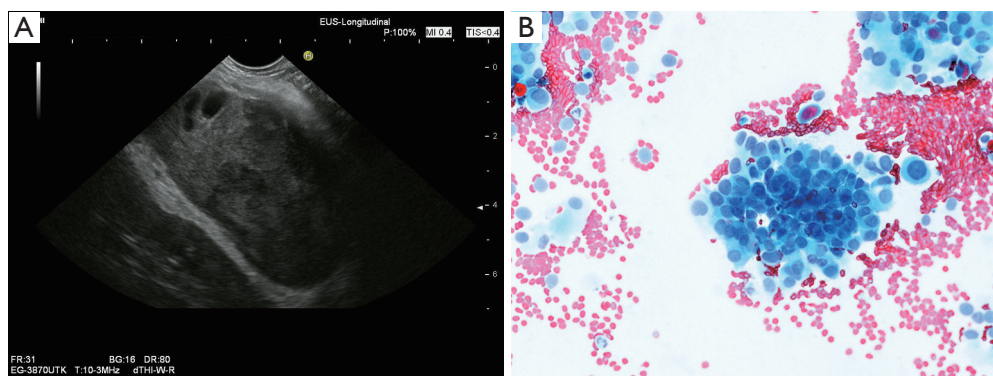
Large hypoechoic, heterogeneous mass lesion of the left adrenal with small cysts in a male patient with radiological suspicion of peripheral lung cancer (A). EUS-FNA was performed using a 22 Gauge-aspiration needle. Smear cytology (B) (Papanicolaou, $\times 200$; immunocytochemistry: CK7 and EMA positive, CD56 and CK5/14 negative) gives proof of poorly differentiated adenocarcinoma, consistent with the clinical suspicion of left adrenal metastasis of NSCLC. Cytological image: courtesy Dr. K. Zels, Königs Wusterhausen, Germany. EUS-FNA, endoscopic ultrasound fine needle aspiration.
